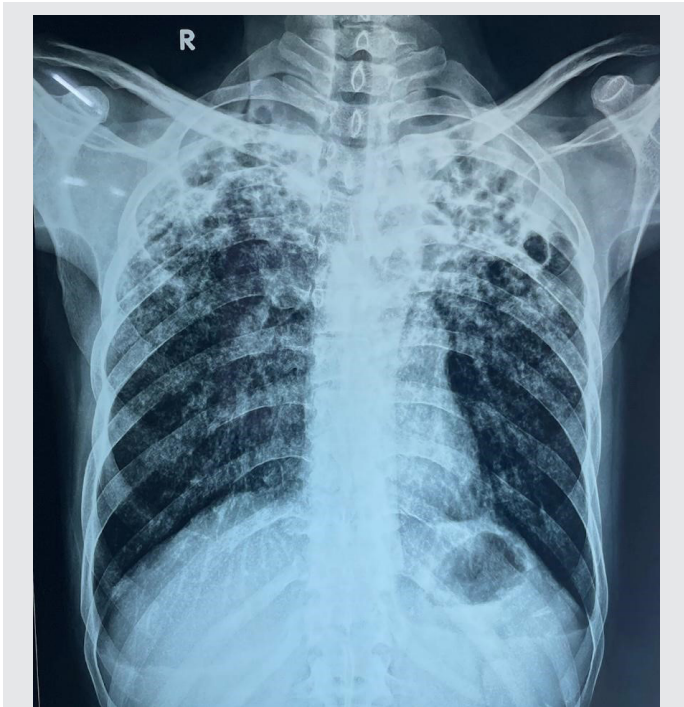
Chest x-ray reveals bilateral upper lobe infiltrates with cavities, especially in the left upper lobe.
